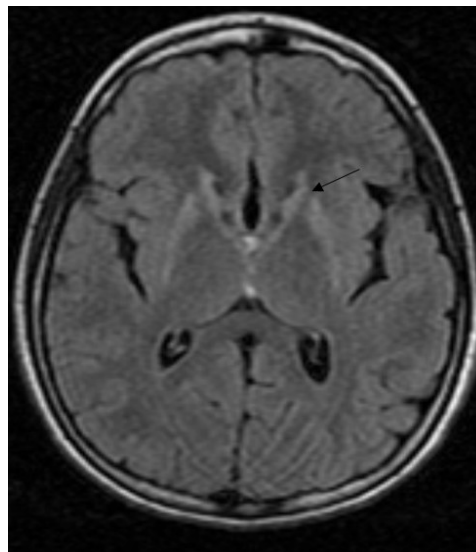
T2-FLAIR image exhibits severe atrophy of the caudat nucleus heads (black arrow).
